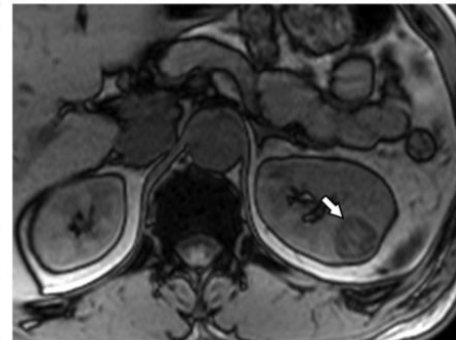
Papillary RCC in a 47-year-old man with a renal lesion corresponding to that in Figure 4 seen at chest computed tomography (CT). (a) Axial T2-weighted image shows a 2.8-cm hypointense renal mass (arrow). (b, c) Axial in-phase (b) and opposed-phase (c) T1-weighted images show a drop in signal intensity on the in-phase image (arrow in b) compared with that on the opposed-phase image (arrow in c), consistent with hemosiderin. (d, e) Corticomedullary phase (d) and nephrographic phase (e) axial 3D fat-saturated SPGR T1-weighted images show mild enhancement (arrow).
